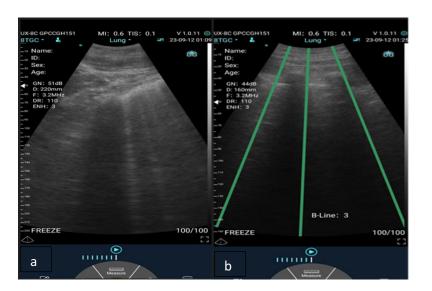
B lines detected in the lung ultrasonography of participants (a) ET and (b) CB).
